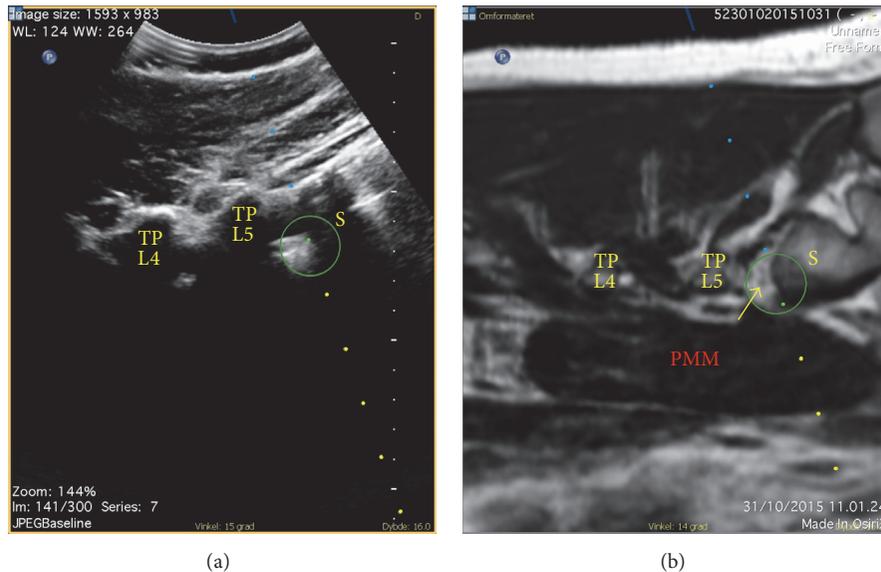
The ultrasonographic (a) and MR (b) images are fused and displayed side-by-side. The blue line in the top is the projection of the block needle and the large green circle marks the anticipated intersection of the block needle tip and the ultrasound beam, here coinciding with the rami of spinal nerve L5 (yellow arrow) displayed on the MR image. The line of small blue and yellow dots marks the anticipated trajectory of the block needle prior to and after the intersection with the ultrasound beam, respectively. PMM, major psoas muscle; S, sacral ala; TP L4-5, transverse processes of the fourth and fifth lumbar vertebral bodies.
